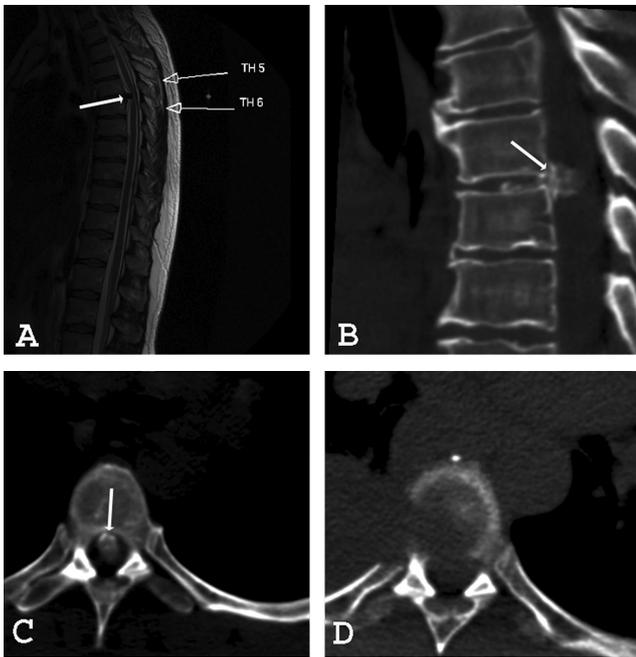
Sagittal T2-weighted MRI disclosing a median herniated disc at T5–T6 (A), and calcification at sagittal CT (B) as well as on the transversal CT (C) (white arrow). D, At the postoperative transversal CT, a complete removal of the calcified herniated disc was seen. The right-sided partial corpectomy defect is also clearly seen.
